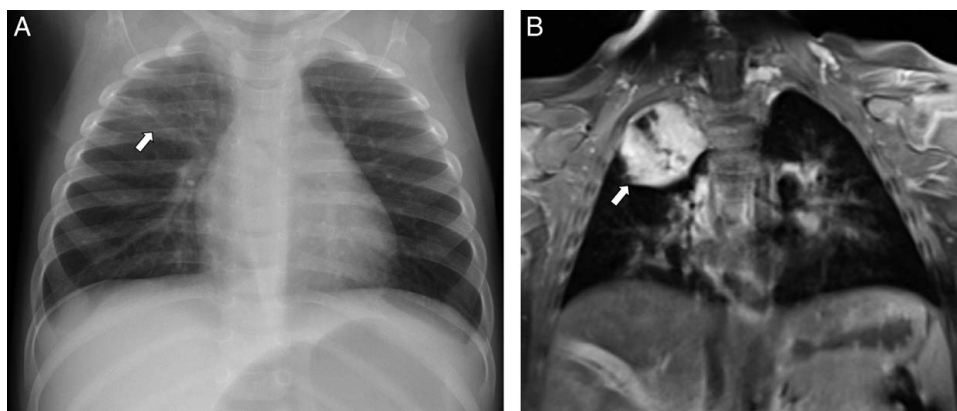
A 9-month-old girl with right upper lobe pneumonia. A, Frontal chest radiograph demonstrates right upper lobe hazy opacity (arrow). B, Coronal T2-weighted fat suppressed MR image shows right upper lobe hyperintense consolidation (arrow).
